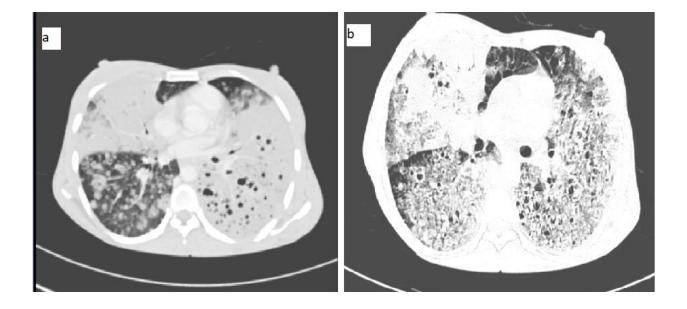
a) Contrast Enhanced Computed Tomography (CECT) of the chest showed right upper lobe and left lung necrotizing consolidation with right lung lower lobe cavitating nodules. b) Bilateral all lung lobes necrotizing consolidation, which has progressed from cavitating nodules to necrotizing consolidation.
